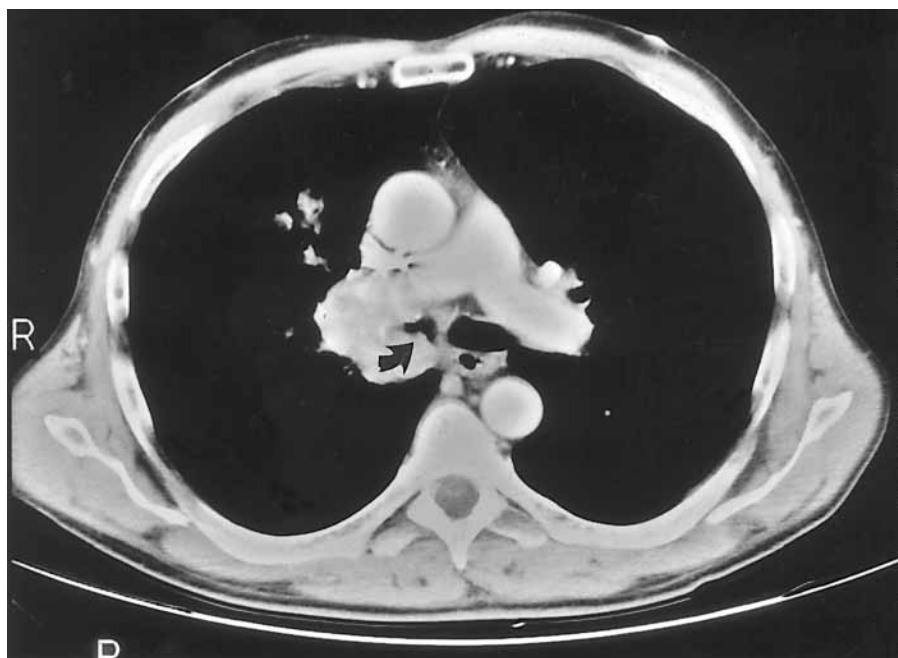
CT scan at the level of the main carina of a 54-year-old male smoker with blood-tinged sputum. High suspicion of locally advanced right upper lobe tumor with invasion of the mediastinum and partial obstruction (curved arrow) of the right main bronchus.
